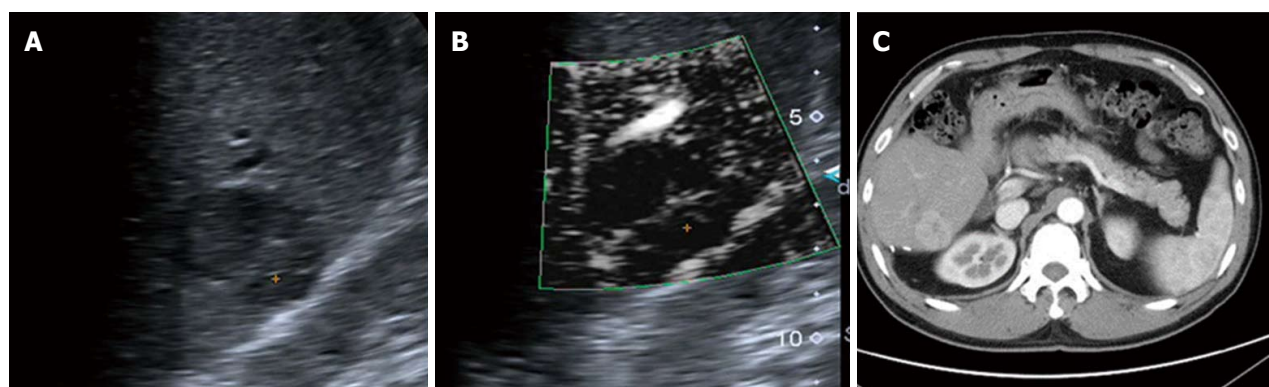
Non-specific type (type V) in a 48-year old male diagnosed with hepatic cellular carcinoma. A: A low-echo lesion with a relatively clear margin was evident in the right liver lobe; B: SMI showed a microvascular distribution of a strip trunk with tiny branches; C: Contrast-enhanced CT showed diffuse enhancement of the lesion in the arterial phase. SMI: Superb microvascular imaging.
